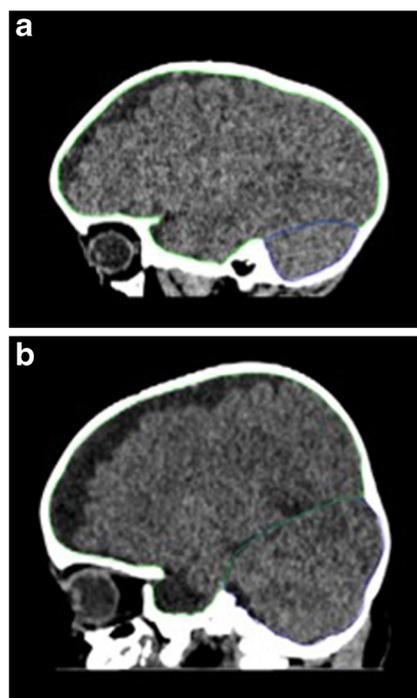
Manual delineation of supratentorial and infratentorial compartments on sagittal CT using OsiriX software. a Sagittal craniosynostosis CT scan; b control CT scan (normal head shape)
